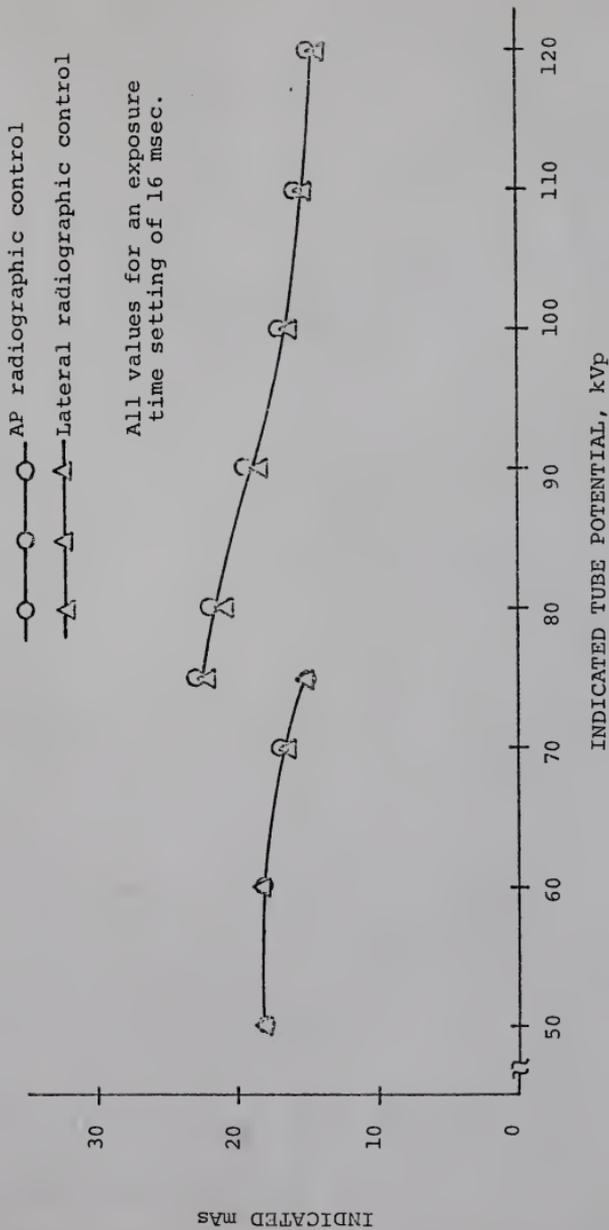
Indicated mAs for X-ray Tube Potential Settings on Philips "Maximus-100" Generators Operating in Iso-watt Falling Load Mode.
